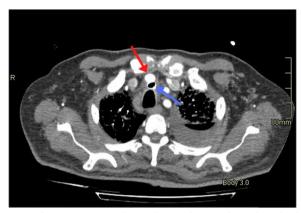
Chest- CT angiography (axial view), showing the endotracheal tube (blue arrow) located outside the trachea and in contact with the posterior wall of the innominate artery (red arrow)
